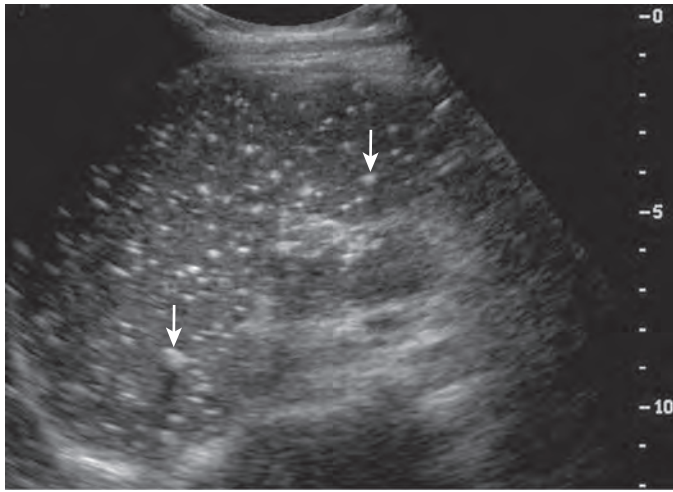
Candidiasis. For a leukemia patient with a history of *Candida* infection, sonography demonstrates innumerable, punctate, hyperechoic foci (arrows) throughout the spleen, consistent with healed granulomas.
